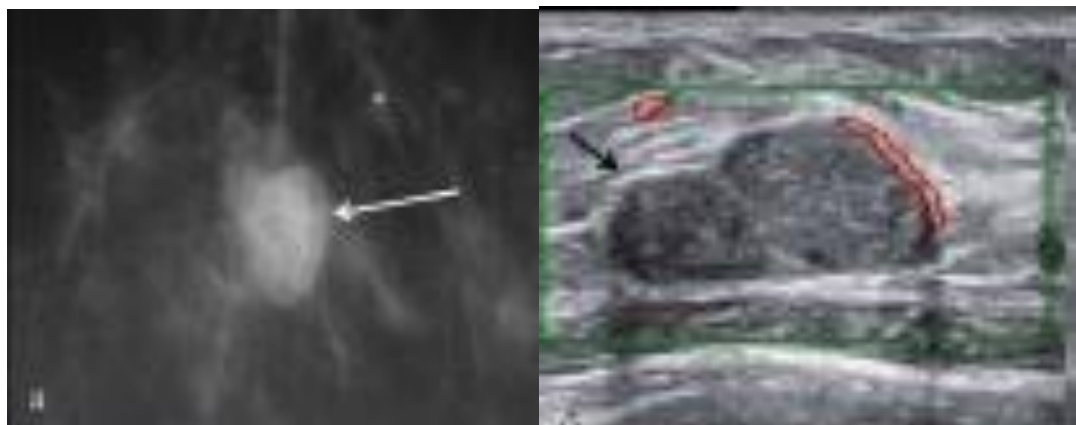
Patient N., 66 years old. X-ray mammography; a fragment of a mammogram in a direct projection (a), an ultrasound study using energy Doppler mapping (b). Pericardial fibroadenoma. The formation of an oval shape with even clear contours, a moderately heterogeneous structure (arrow) is determined, peripheral blood flow is noted. Microcalcifications are detected in nearby tissues.
